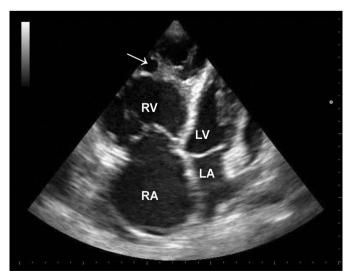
Apical 4 chambers view. Dilated right heart cavities, right ventricle trabeculae are seen (arrow)
